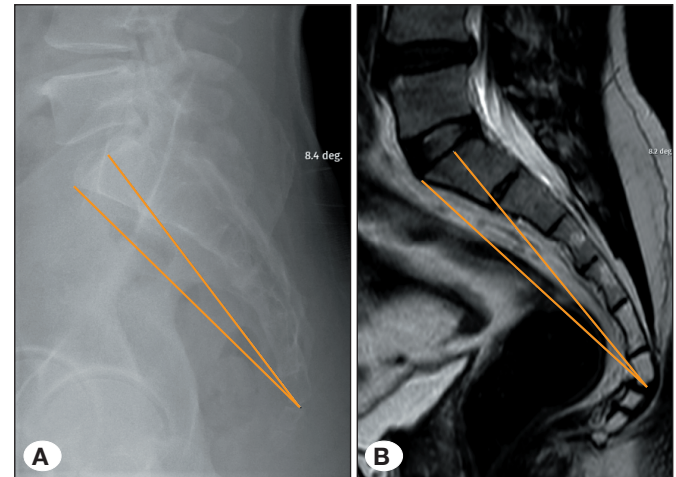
Lateral lumbosacral radiogram (A) and T2-weighted magnetic resonance mid-sagittal image of the lumbosacral vertebrae (B) of a patient with sacralization. The measurement of the ATA2 on radiograph and magnetic resonance image is shown in (A) and (B), respectively.
